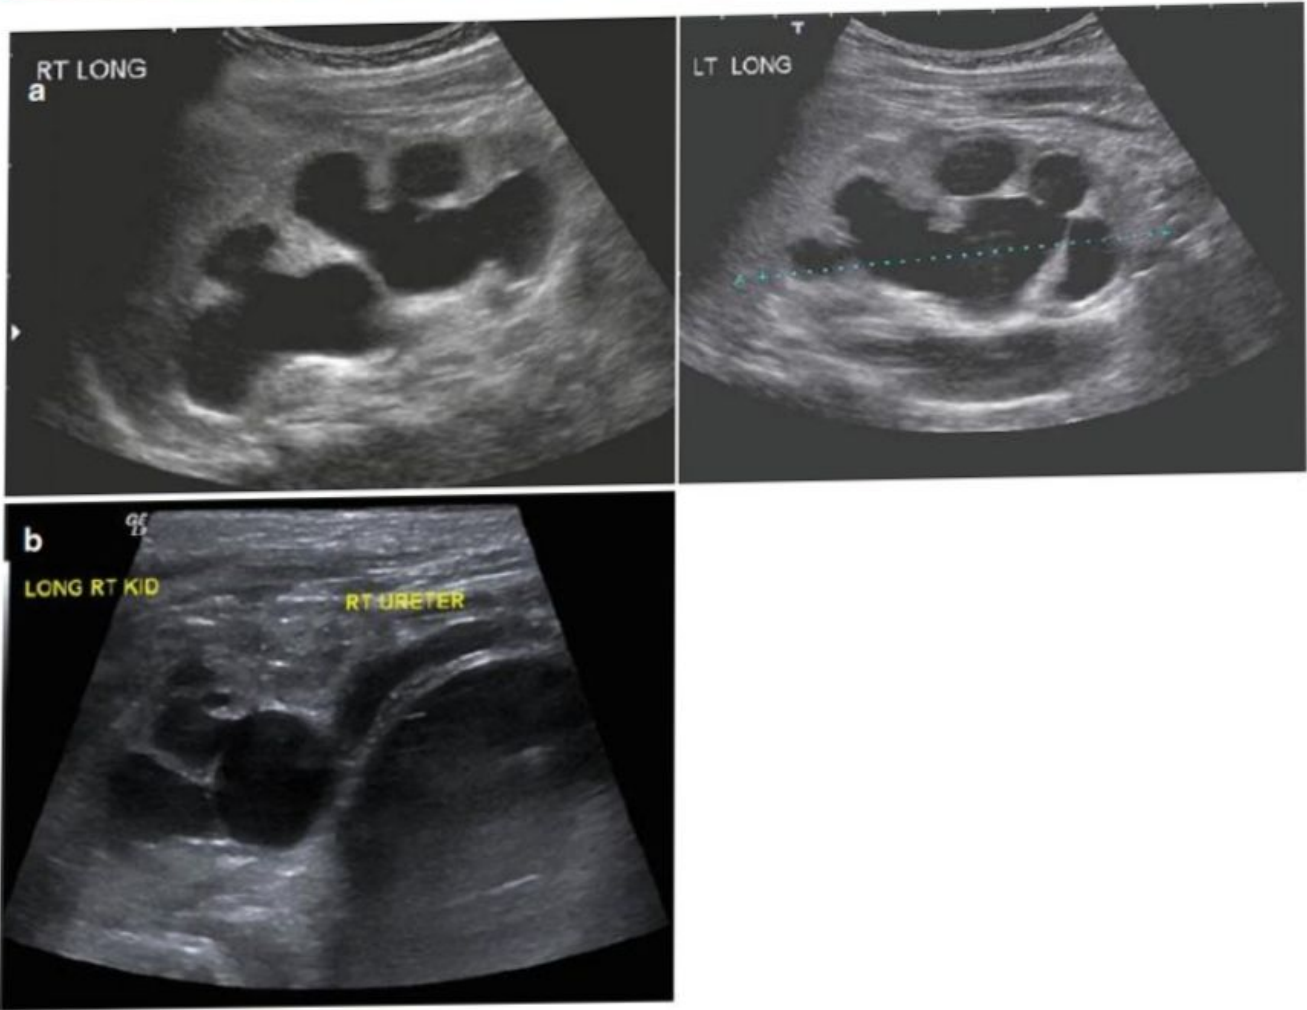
Hydronephrosis (ultrasound image). (a) Bilateral hydronephrosis. (b) Hydronephrosis and megaureter
